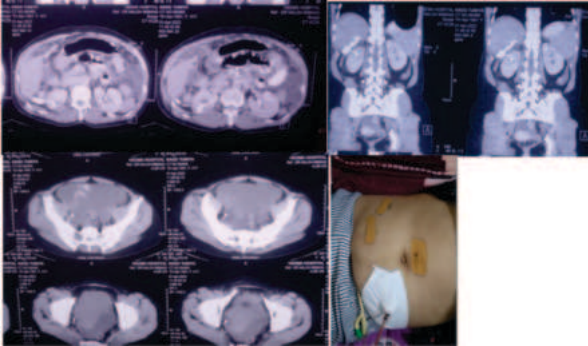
PostD PCNL CT images; A,B,C-Images C shows Urinary extravasation from the PCS and free fluid into the peritoneal cavity. D- Post Diagnostic laparoscopy port site
